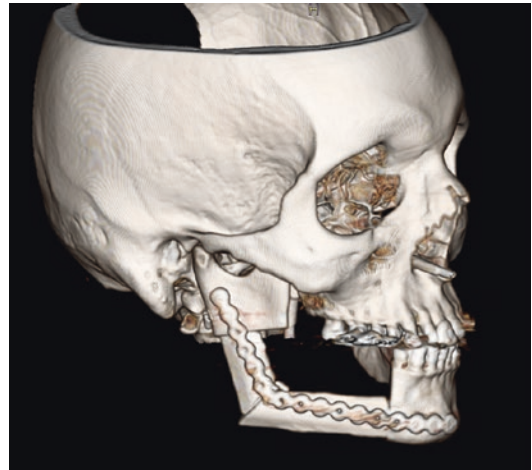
Postoperative 3D CT of fibular flap reconstruction for Brown Class I mandibulectomy
